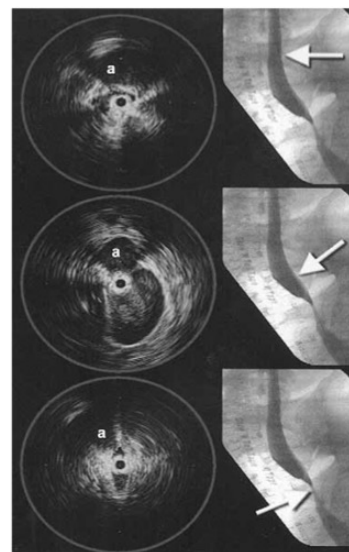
Several iliac venous intravascular ultrasound scan (IVUS) images (*left*) and transfemoral venogram (*right*) obtained in post-thrombotic limb. On IVUS images, iliac artery (*a*) is in similar position and catheter can be seen in vein (*black circle*). Arrows on venogram indicate levels where IVUS images were obtained. With transverse orientation of stenosis with IVUS, venogram appearance may be near normal despite severe stenosis (*top*) as compared with sagittal orientation of the stenosis, when findings on IVUS and venogram correspond (*bottom*). *Middle images* show nonstenotic vein on both investigations.
